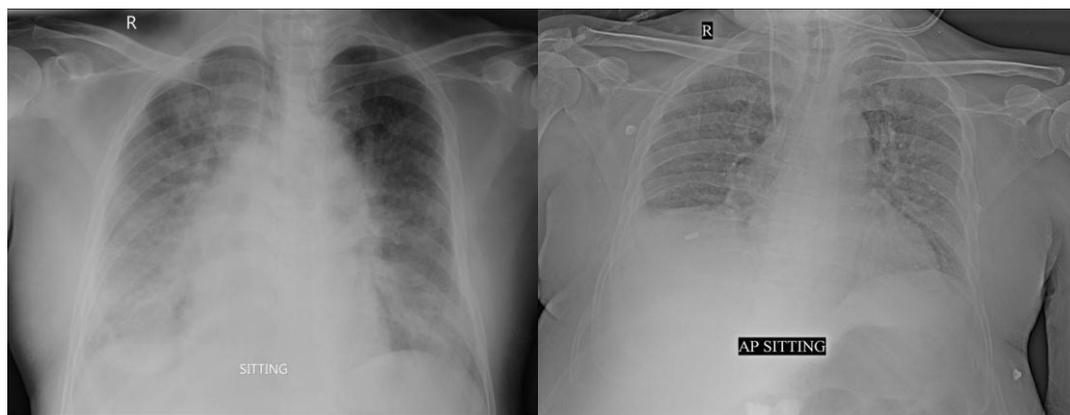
(a,b): Chest Radiograph showing no pleural effusion on either side in (a); Post nasogastric tube insertion there is development of right pleural effusion due to wrongful insertion of nasogastric tube into right lower lobe bronchus.
